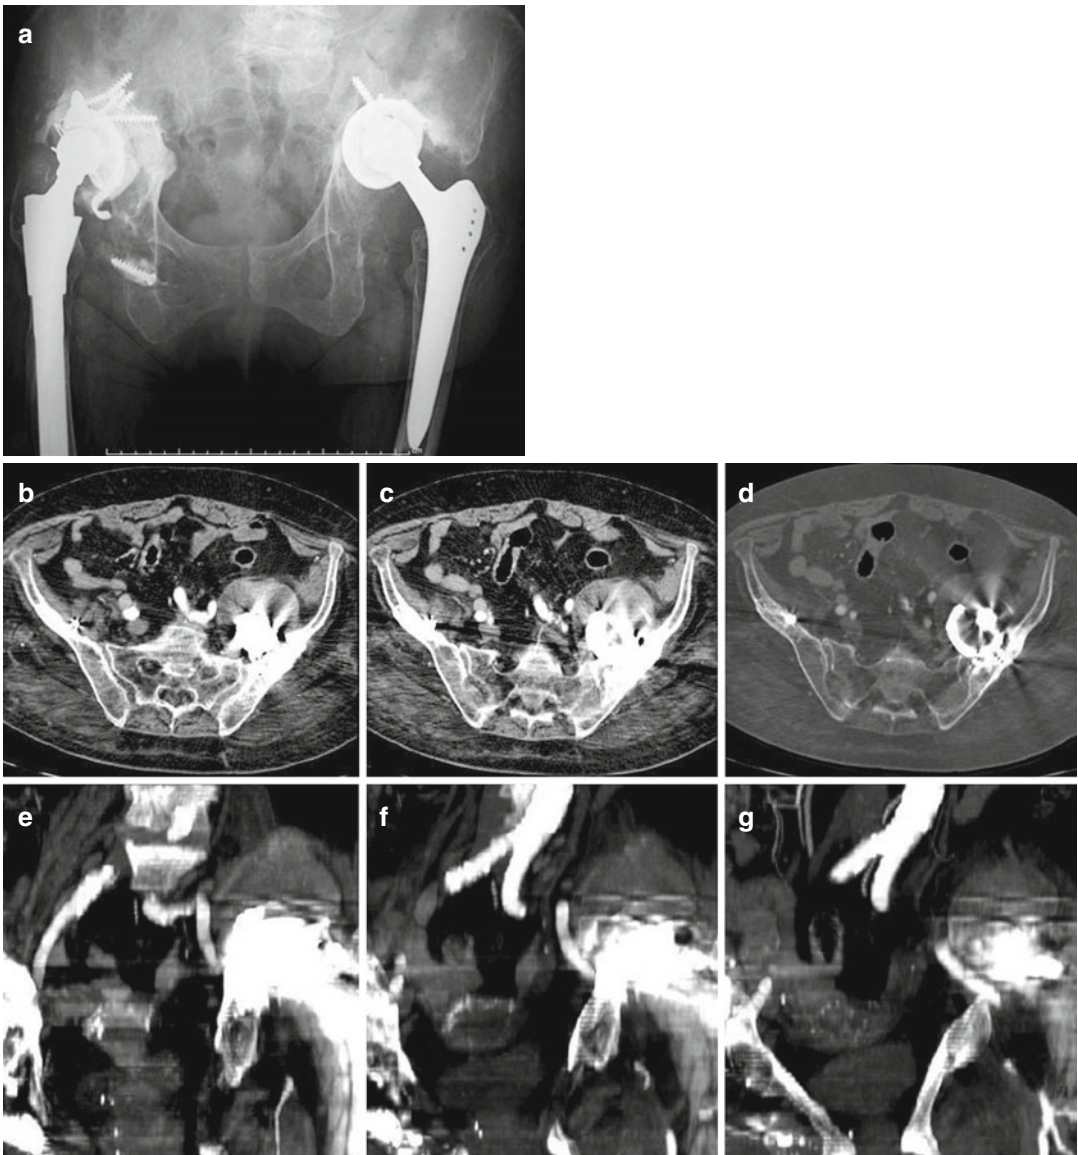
Broken left acetabulum in aseptic loosening of total hip replacement: pelvis radiography (a). CT axial (b–d) and reformatted (e–g) for surgical planning to show bone-vessel relations. X-ray controls after surgery (h)
